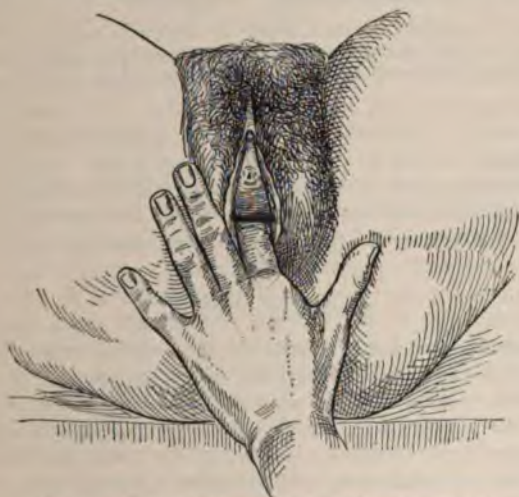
DIRECT INSPECTION OF THE VAGINA (page 230).
